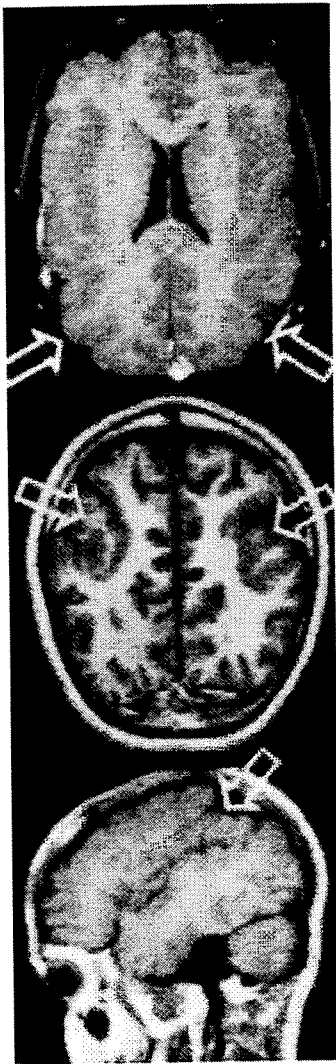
(Patient 11). Axial, coronal and sagittal T1-weighted images showing polymicrogyria around the Sylvian fissure.
